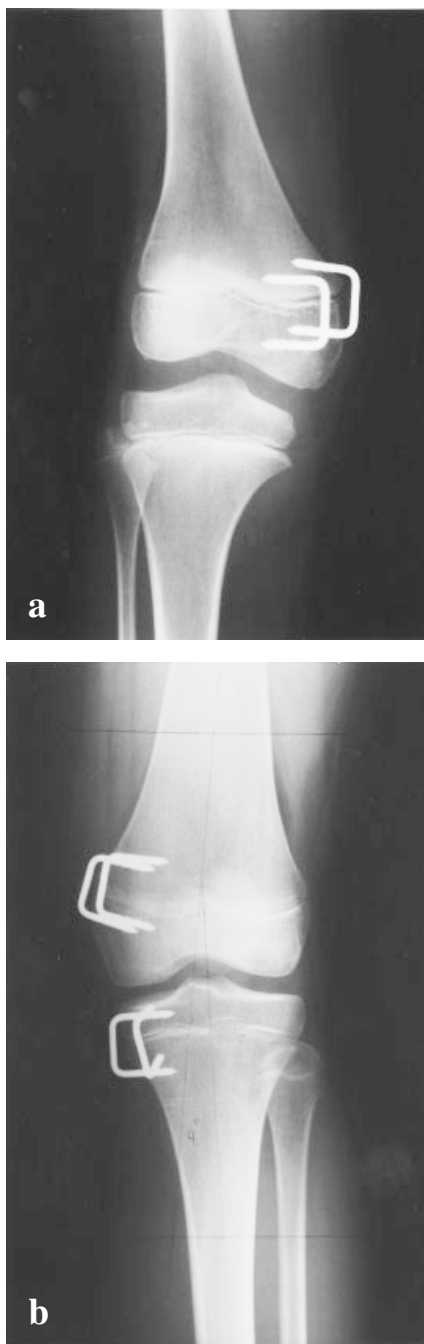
Native X-rays taken in two of the study patients, demonstrating medial stapling due to valgus deformity in the (a) distal femur, and (b) distal femur and proximal tibia.
